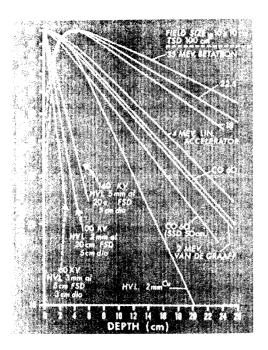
Central axis depth dose curves for X-ray beams from 60 KV to 35 MV and Co-60 in water.
